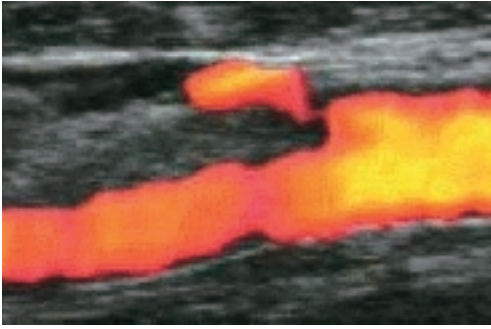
Colour Doppler ultrasound of the internal carotid artery shows a visibly patent vessel.
